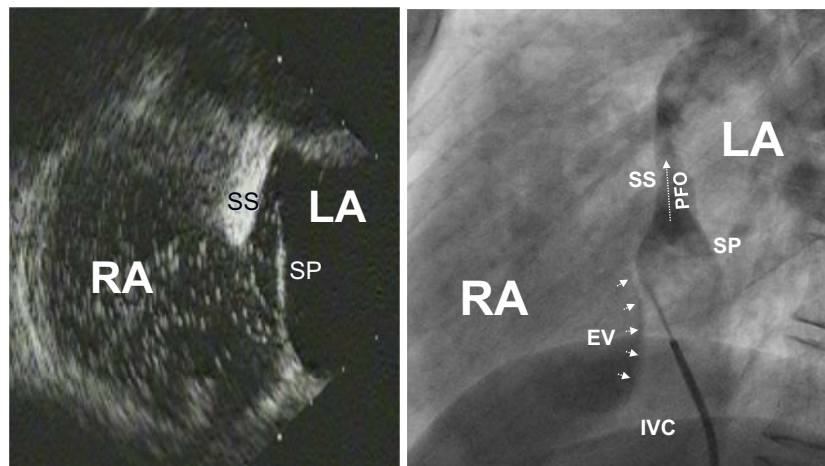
Definite documentation of a PFO by transesophageal echocardiography obtained during an agitated saline bubble study (left, placed in the projection corresponding to angiography) and angiography (right) with iodinated contrast medium. EV, Eustachian valve; IVC, inferior vena cava; LA, left atrium; RA, right atrium; SP, septum primum; SS, septum secundum.
